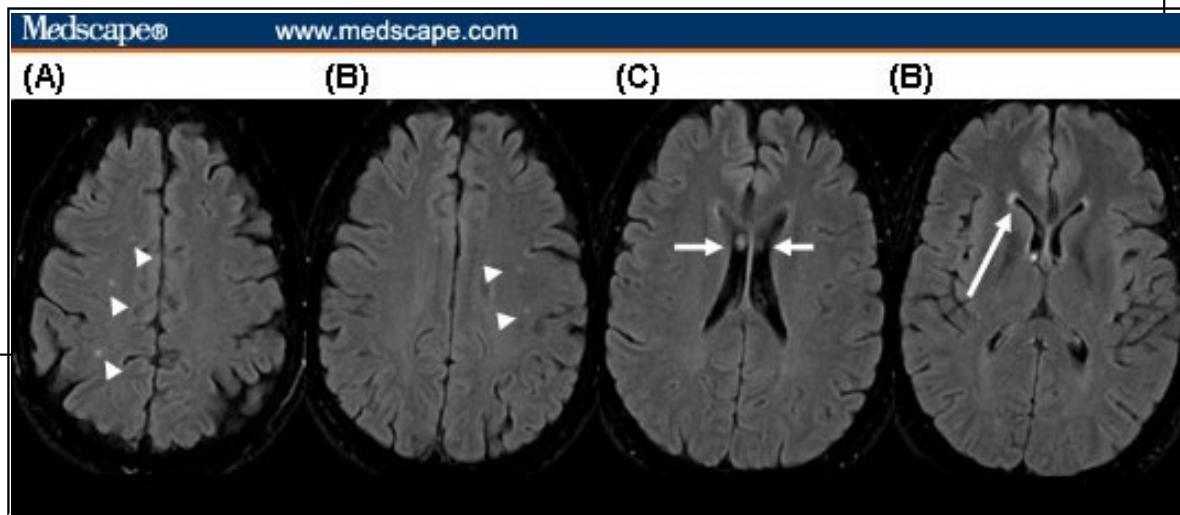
FLAIR variants and artifacts. Small peripheral hyperintensities on FLAIR MRI (arrowheads in [A] and [B]) can be seen in normal aging or patients with migraine headaches. Intraventricular pulsation artifact (arrow, [C]) occurs in areas of fast-flowing CSF, such as near the foramen of Monro or the fourth ventricle. Ventricular "capping" (arrow, [D]) is a normal finding that occurs at the frontal and posterior horns of the lateral ventricles and is important to distinguish from the periventricular lesions of MS.
